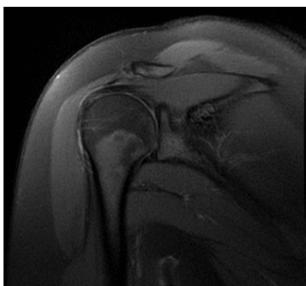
T2 Coronal section on MRI
